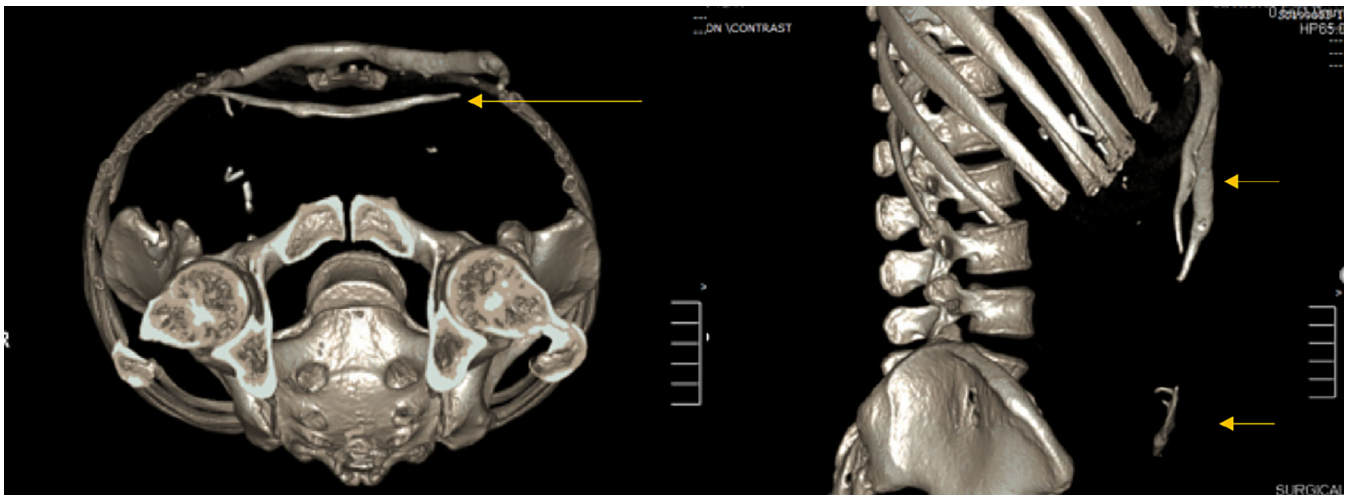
Abdominal computed tomography showing abdominal heterotopic ossification in the anterior abdominal wall.
